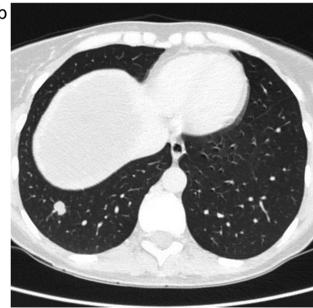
a,b: CT scan – 2 lung nodules in the right lower lobe.
